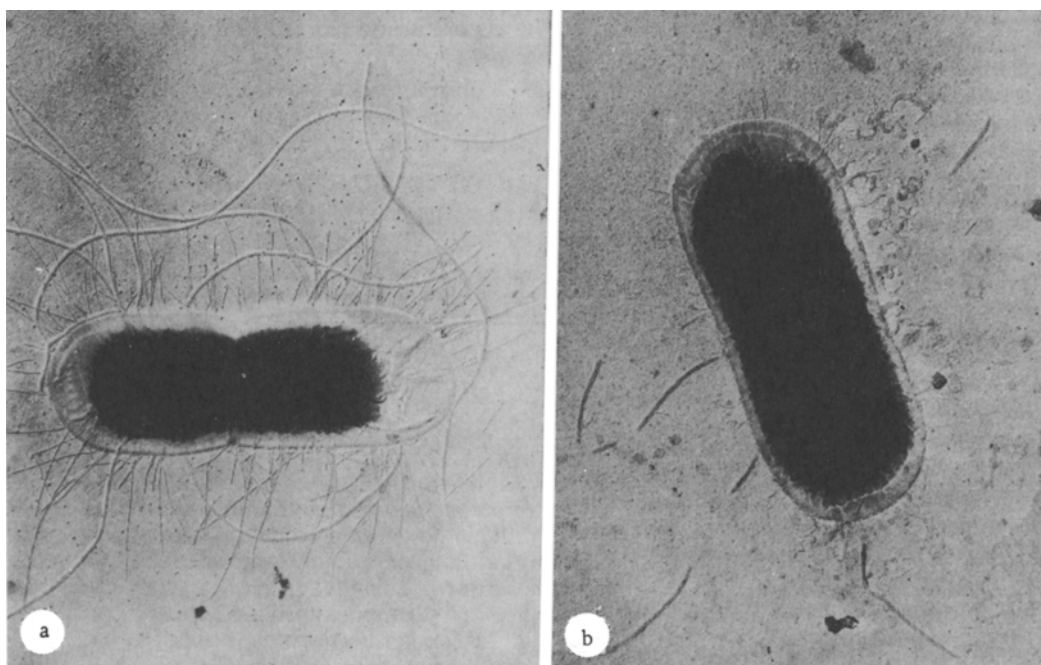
Effect of ultrasound on morphology of *E. coli* strain 815. a) *E. coli* cell before treatment with ultrasound. Type I pili and flagella can be seen; b) *E. coli* cell after treatment with ultrasound. Fragments of flagella and pili are visible. Arrows indicate partial release of cell contents. Sprayed with platinum and palladium. 30,000  $\times$ .
